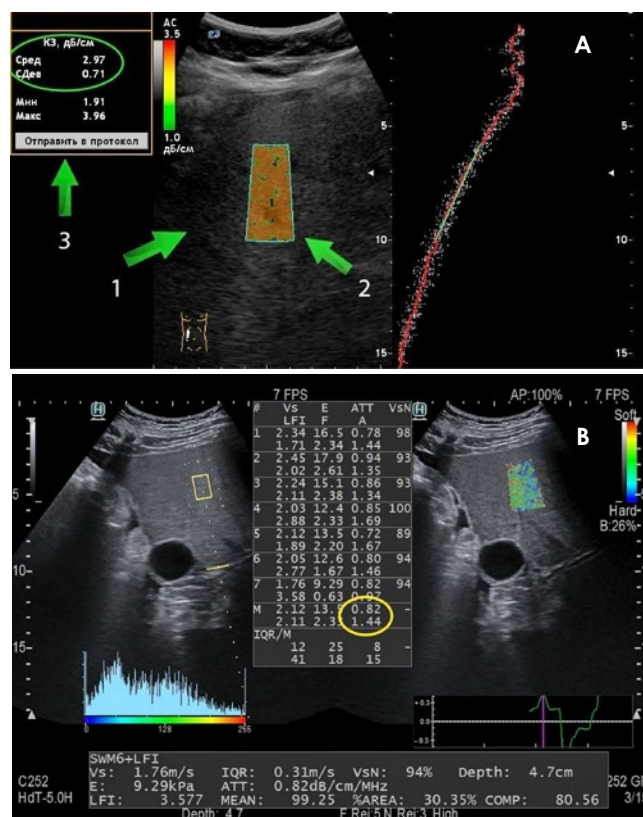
A. Window of results of ultrasound steatometry: 1 – liver, 2 – active zone of measurement, 3 – short-circuit indicator of the ultrasound wave. B. Window of results of combined elastography: 1 – liver, 2 – active zone of measurement of short-circuit ultrasound wave, 3 – indicator of short-circuit ultrasound wave, quantitative indicator of inflammatory activity (A-index), quantitative indicator of the severity of liver fibrosis (F-index).
